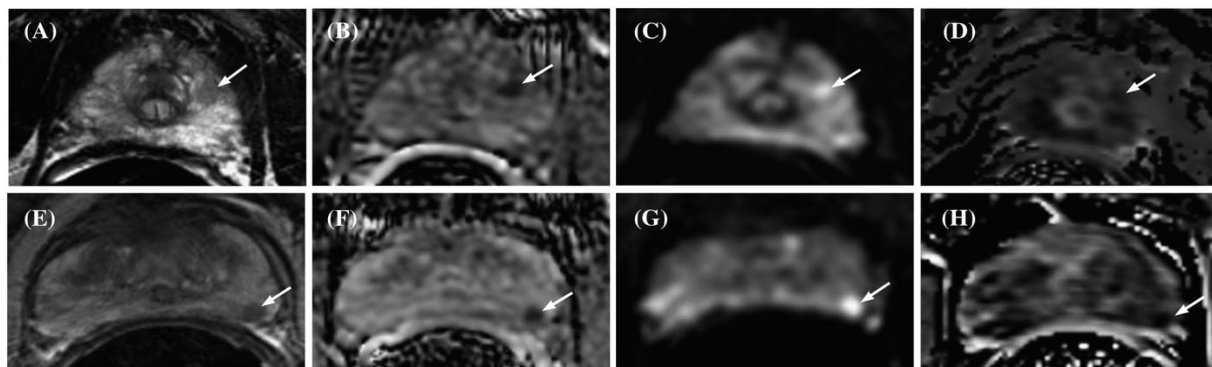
Example prostate MR images from a 67-year-old (GS3+3, PSA=4.6 ng/ml) untreated male (top panel: A-D) and from a 57-year-old man (GS3+3, PSA=0.42 ng/ml) treated with 5 α -reductase inhibitors (bottom panel: E-H). T2w intensity images (A, E), ADC (B, F), high-b value DWI intensity (C, G), and washout slope (D, H) images are shown. The arrows designate cancerous regions.
